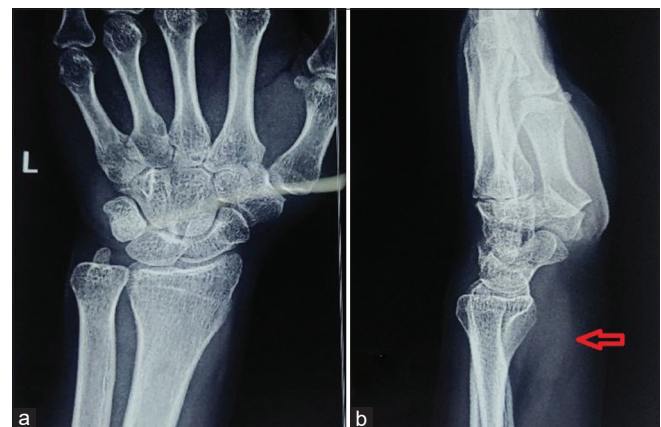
Preoperative X-ray of left wrist (a) and (b) lateral view of left wrist showing the soft tissue shadow (red arrow)
